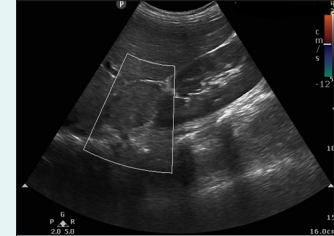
Colour Doppler study
